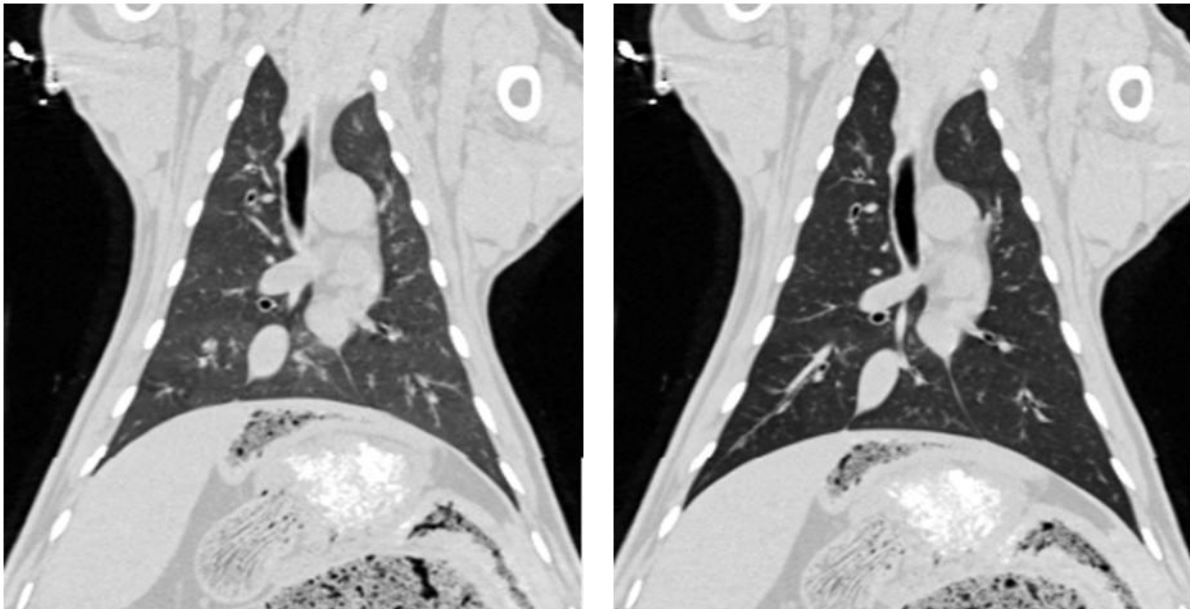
Sample CT scans for a lung at two different lung volumes.
